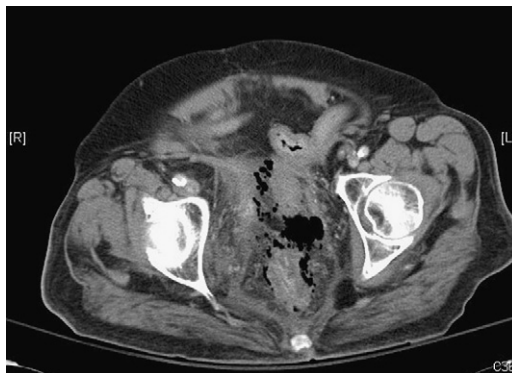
Rectal perforation with extraperitoneal air seen on CT scan. (Courtesy of Joel Goldberg, MD, Boston, MA.)
